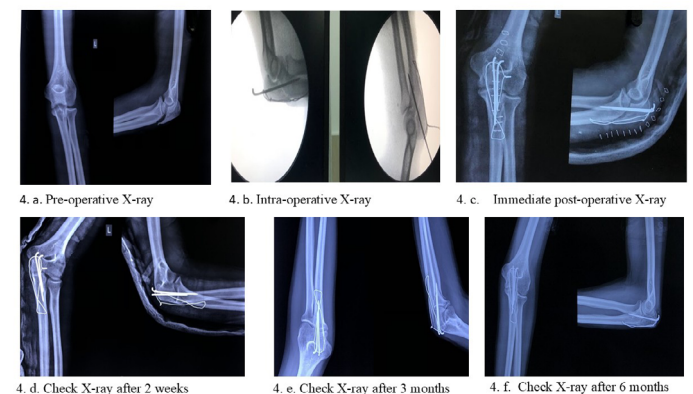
Pre-operative, intra-operative, and post-operative X-ray images
